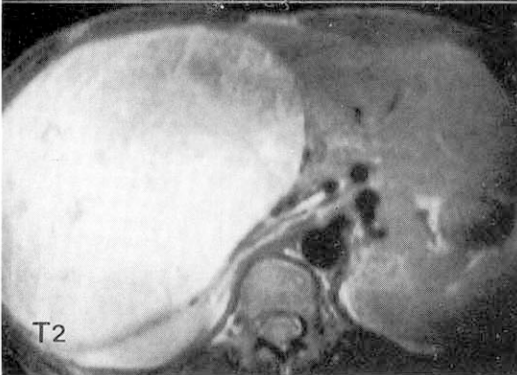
MRI: On T₁ weighted image, the mass shows hyper- and isodensity lesion compared to normal liver, but on T₂ weighted image it shows bright signal intensity.
